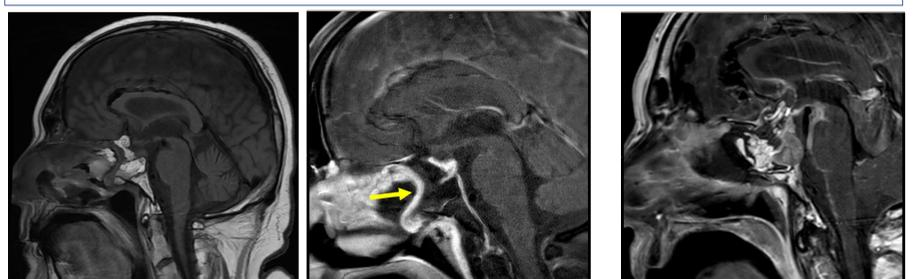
Case 1. Postoperative MRI
